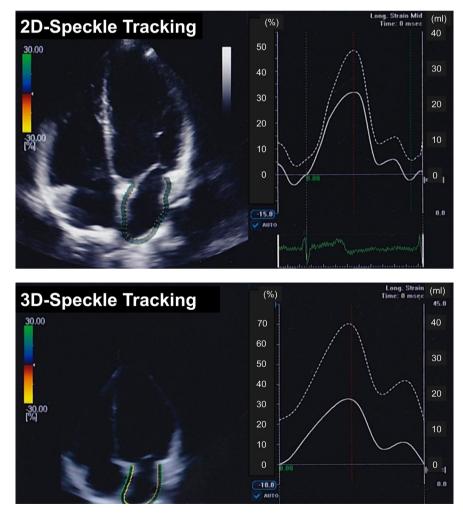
Representative image of two-dimensional speckle tracking echocardiography and three-dimensional speckle tracking echocardiography. Solid line: time-left atrial strain curve (%); broken line: time-left atrial volume curve (ml).
